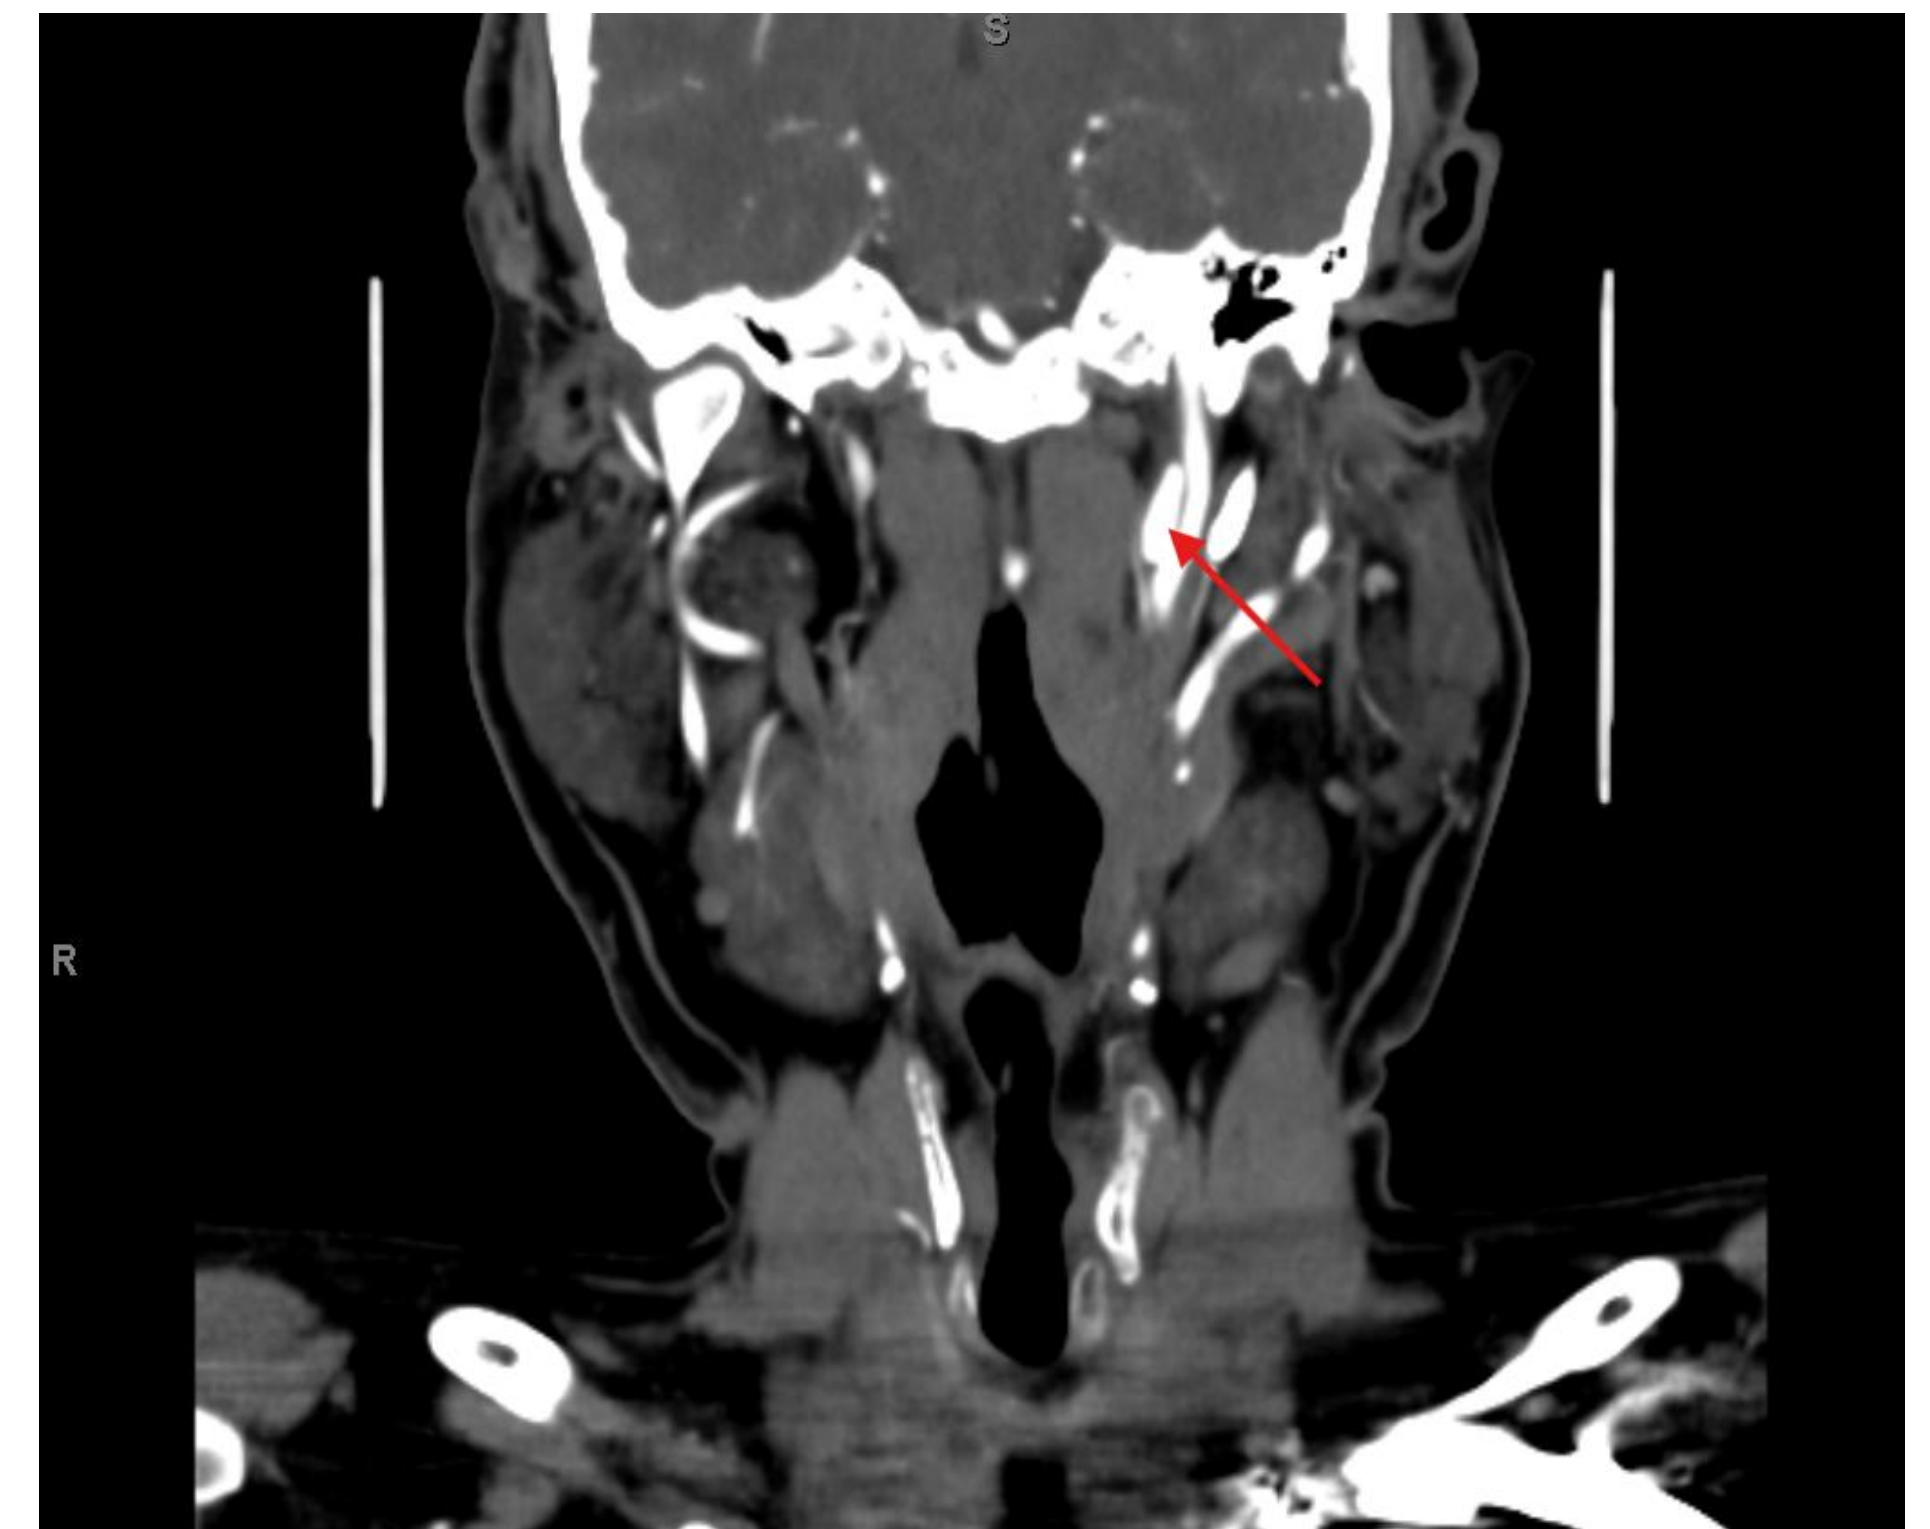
Coronal CT Angiography of the Neck. Red arrow identifying left ICA pseudoaneurysm
